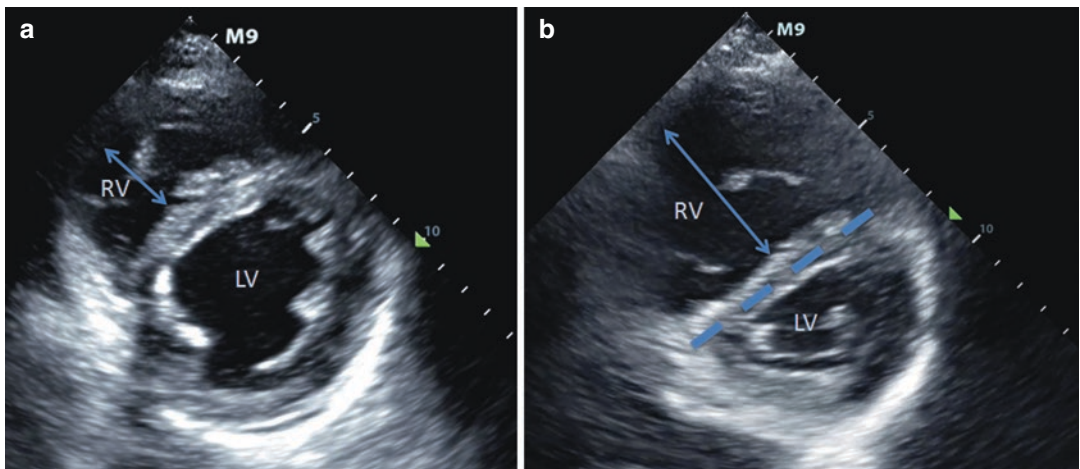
RV-LV size relationship and position of intra-ventricular septum (transthoracic echocardiogram, parasternal short axis). (a) Normal relative RV and LV size, septum forms a contiguous circle with the LV. (b) Dilation
